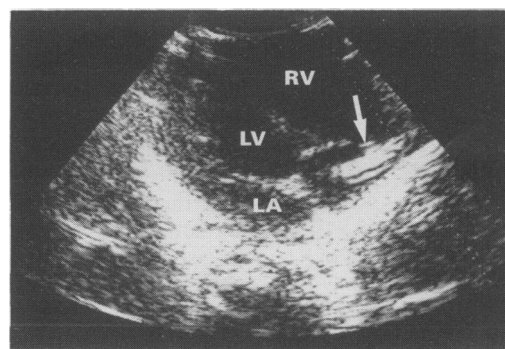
Ultrasound four chamber view of the heart showing the vegetation (arrow) on the tricuspid valve. LV=left ventricle, RV=right ventricle, LA=left atrium.
